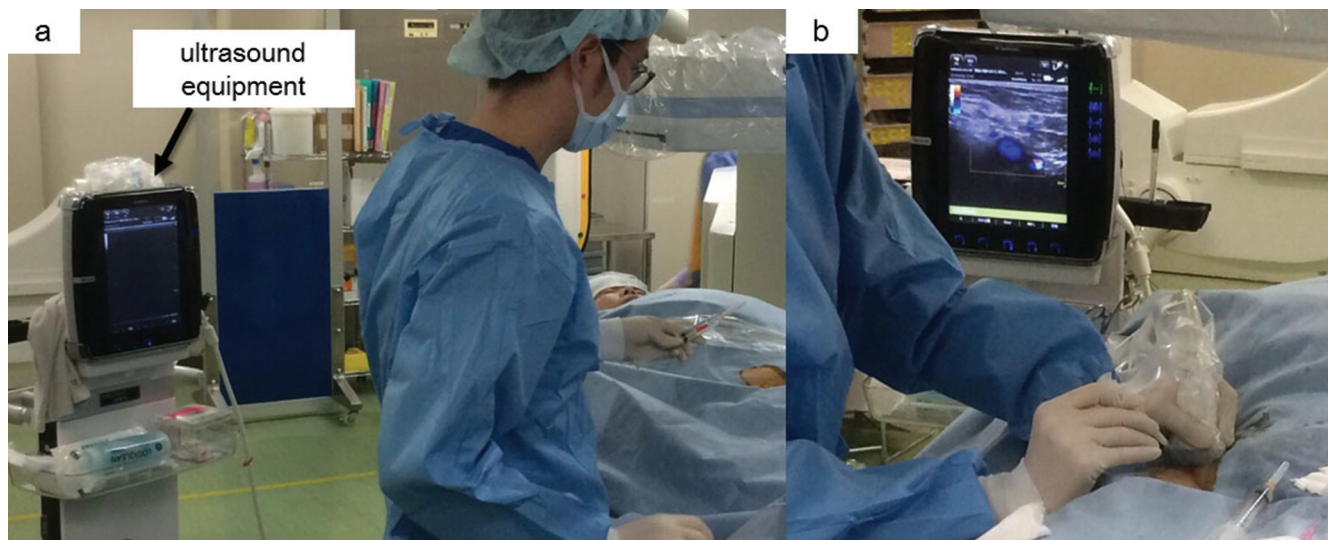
Photographs of ultrasound (US) equipment and angiography suite. a: In order to use an US equipment in our angiography suite, the equipment was placed on the left side of the operator, so that we could watch both fluoroscopic monitor and US monitor at the same time. b: During puncture, US probe was held by the operator's left hand and the 18-gauge needle was handled by his right hand, so that operator could manipulate both the US probe and needle tip in real-time by himself.
